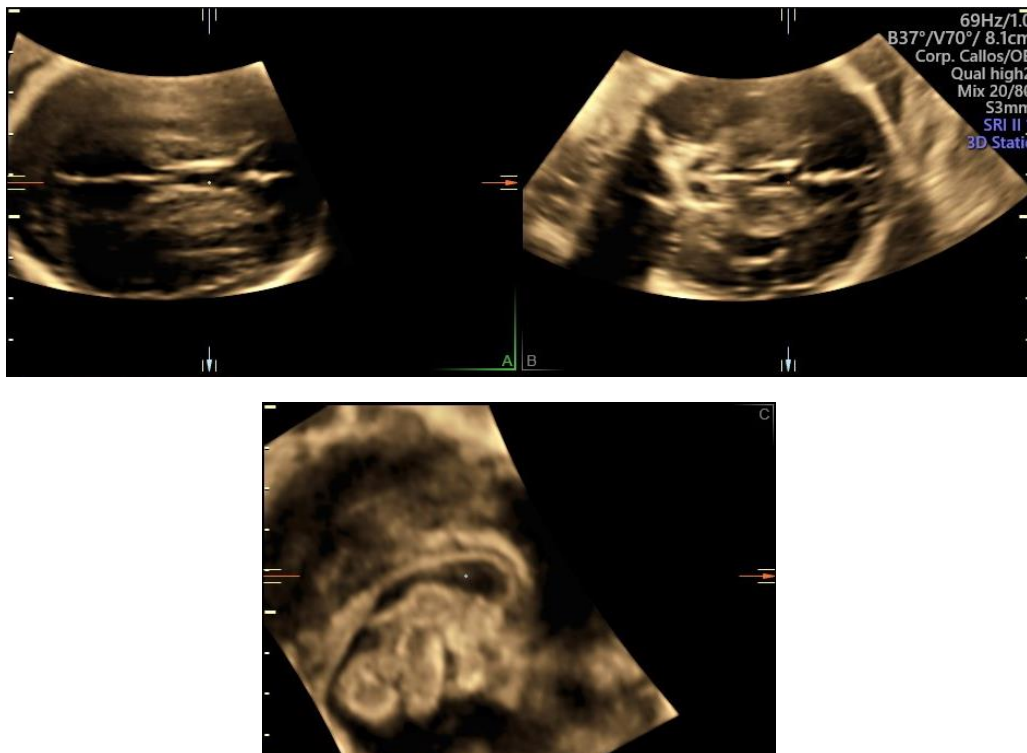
Three-dimensional (3D) ultrasound image of the transventricular plane showing the three orthogonal planes and multiplanar view. Plane A is the axial plane, Plane B the coronal plane and Plane C is the mid-sagittal plane of the fetal brain.
